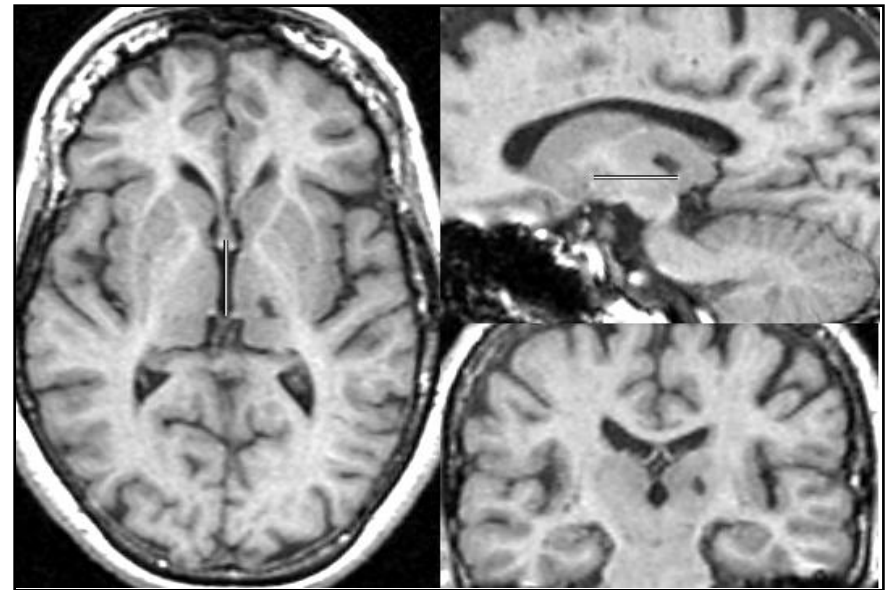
Three dimensional T1 weighted MRI sequence (MP-RAGE): coronal reconstruction according to the bicommissural line, showing the lenticular lesion.
